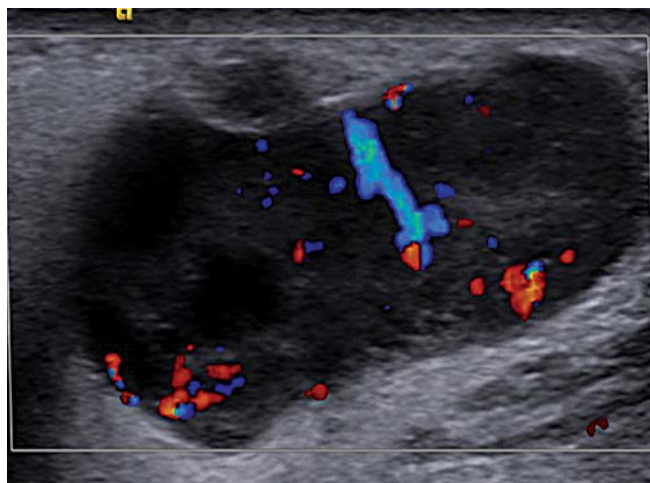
Color-coded duplex sonography of the second tumor in the right parotid gland (1. case). It shows a diffusely vascularized pattern with no characteristic pattern and an anechoic area indicating a cystic area
